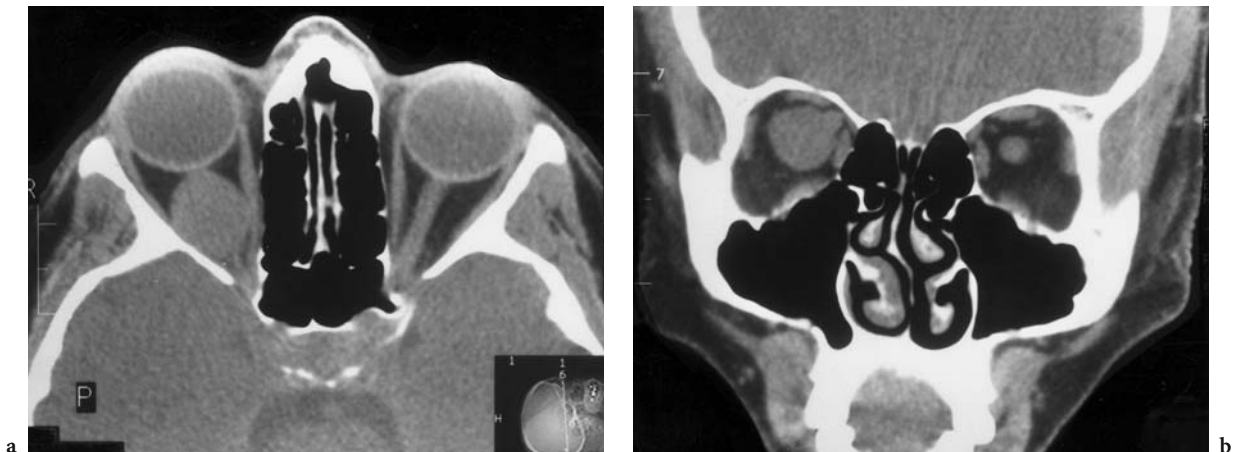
A 61-year-old woman with slowly progressing right axial proptosis and a history of painful pressure in the right orbit associated with a slowly progressing visual deficit. Diagnosis: neurinoma. CT: a Axial medial orbital view, showing a clearly defined intraconal mass, sparing the apex. b Coronal view demonstrates localization inferior and lateral of the dislocated optic nerve
